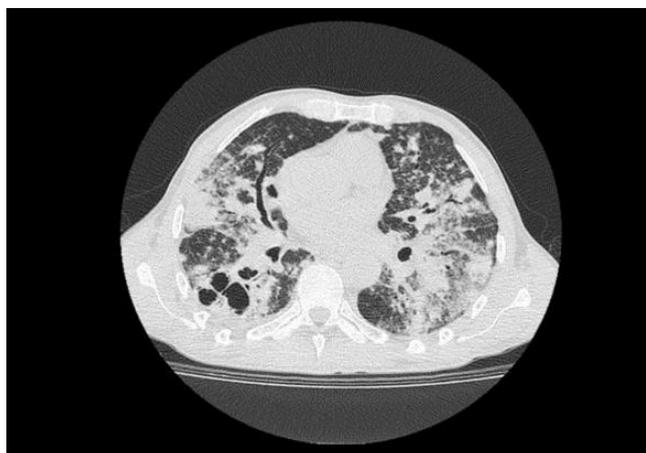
Chest CT scan in axial view, through the lung window, showing multiple bilateral consolidations, with adjacent ground glass. And cavitations in the left lung base. Nonspecific bronchial dilatation in the left middle lung field. Source: Authors.
